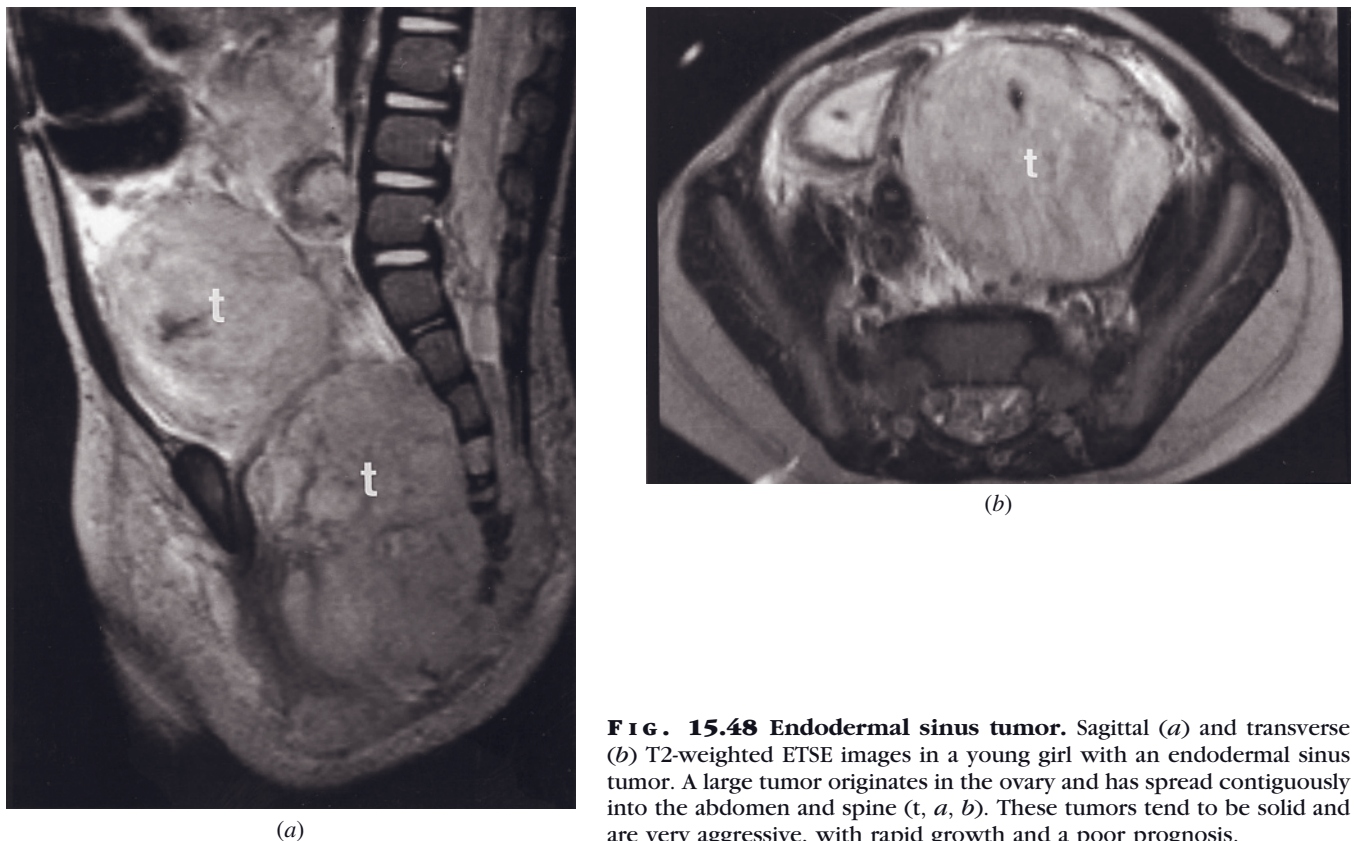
Endodermal sinus tumor. Sagittal (*a*) and transverse (*b*) T2-weighted ETSE images in a young girl with an endodermal sinus tumor. A large tumor originates in the ovary and has spread contiguously into the abdomen and spine (*t*, *a*, *b*). These tumors tend to be solid and are very aggressive, with rapid growth and a poor prognosis.
